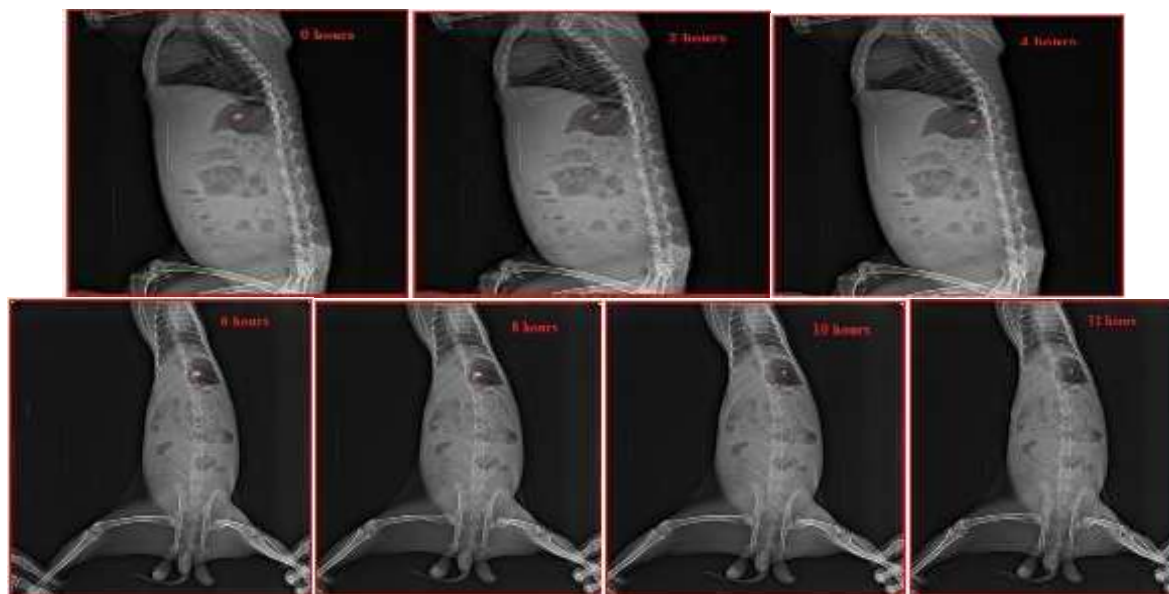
In-vivo X-ray study of best formulation (F7)
